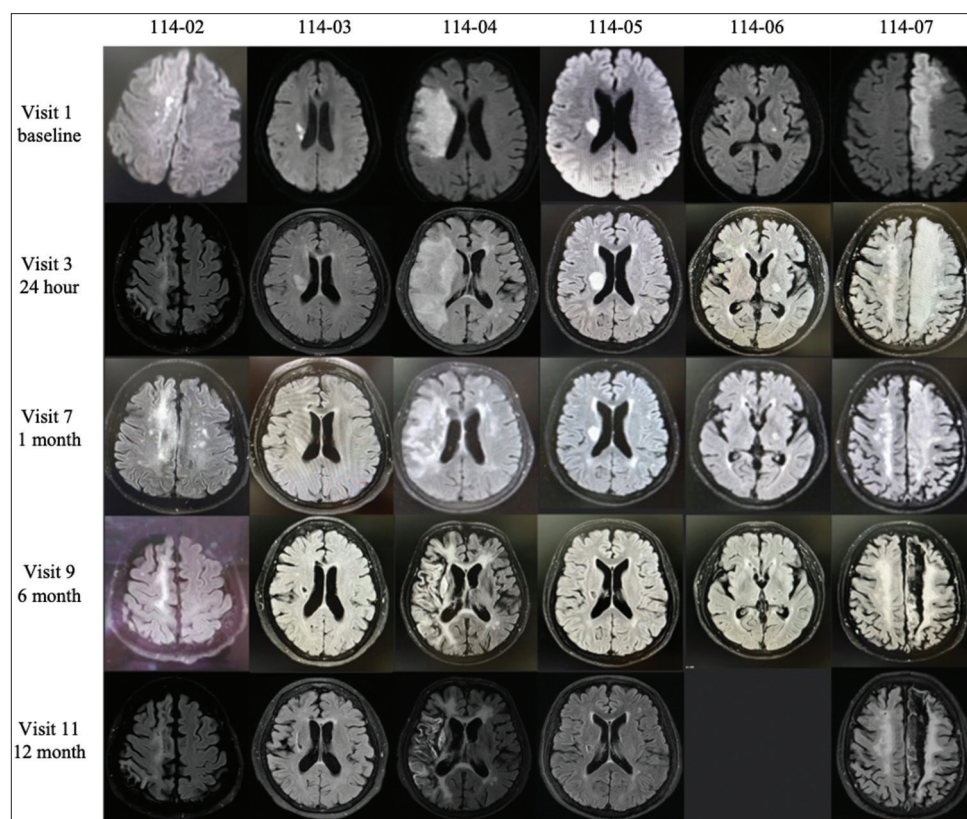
Diffusion-weighted magnetic resonance imaging (MRIs) at baseline and T2-FLAIR MRIs at multiple visits during 12-month follow-ups. Subject no. 114-06 withdrew before visit 11
